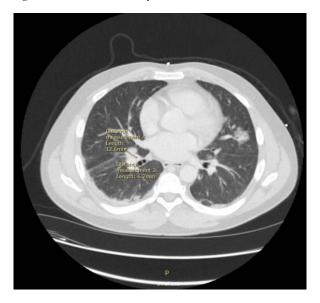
Admission computed tomography of chest, axial view at level of T6-T7. 1) Bilateral pleural cavitations, where right is bigger than left, and mild pleural effusion. 2) Bilateral parenchymal ground-glass opacities and nodules. 3) Enlarged mediastinal lymph nodes where one had central necrosis, measuring 12.6×6.7 mm
